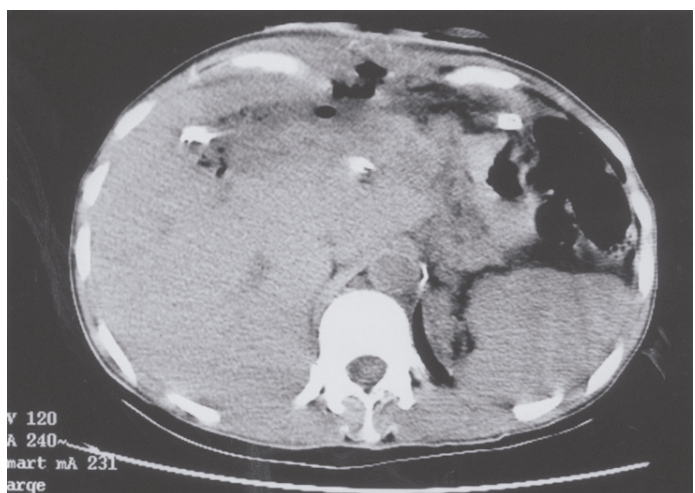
Post-operative CT image of the liver taken two months after surgery shows that most of the mass was removed and the abdomen has regained its normal dimensions (compared with Fig. 1).
